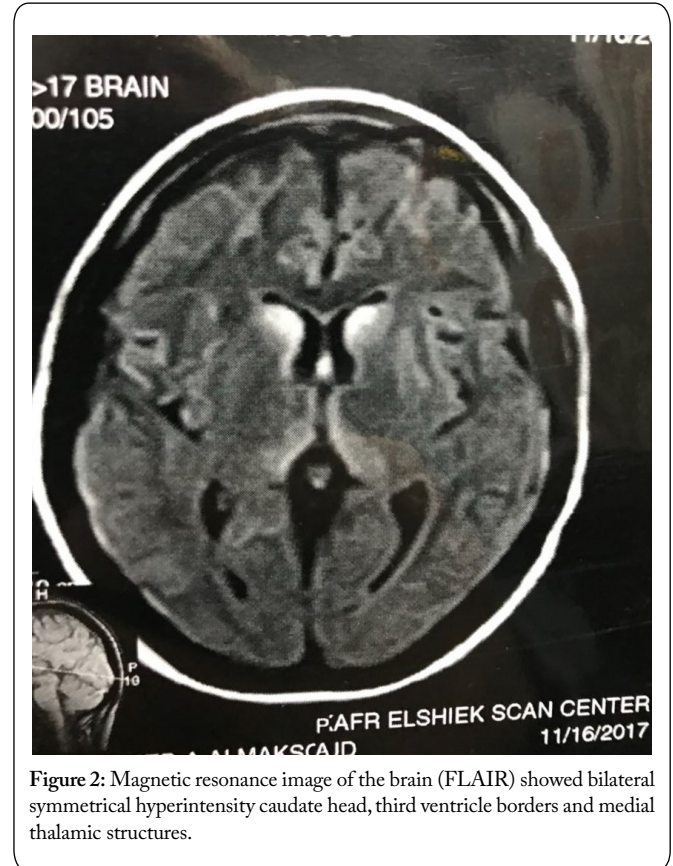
Magnetic resonance image of the brain (FLAIR) showed bilateral symmetrical hyperintensity caudate head, third ventricle borders and medial thalamic structures.
